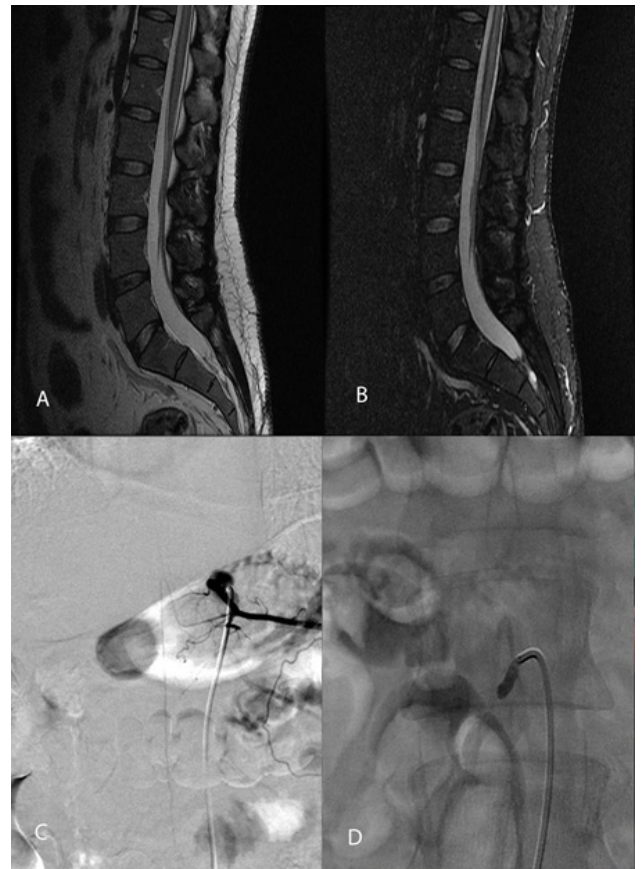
(A) and (B) Spinal magnetic resonance imaging (A) Sagittal T2 weighted image and (B) Sagittal Short-T1 Inversion Recovery (STIR) show linear hyperintensity within central thoracic cord. Increased hyperintensity within central gray matter with sparing of spinal cord periphery is suggestive of acute ischemic lesion. (C) and (D) Angiographic study. (C) Normal left artery of Adamkiewicz (D) Lumbar 2 right segmental artery with proximal obliteration suggestive of steno-occlusive dissection.
